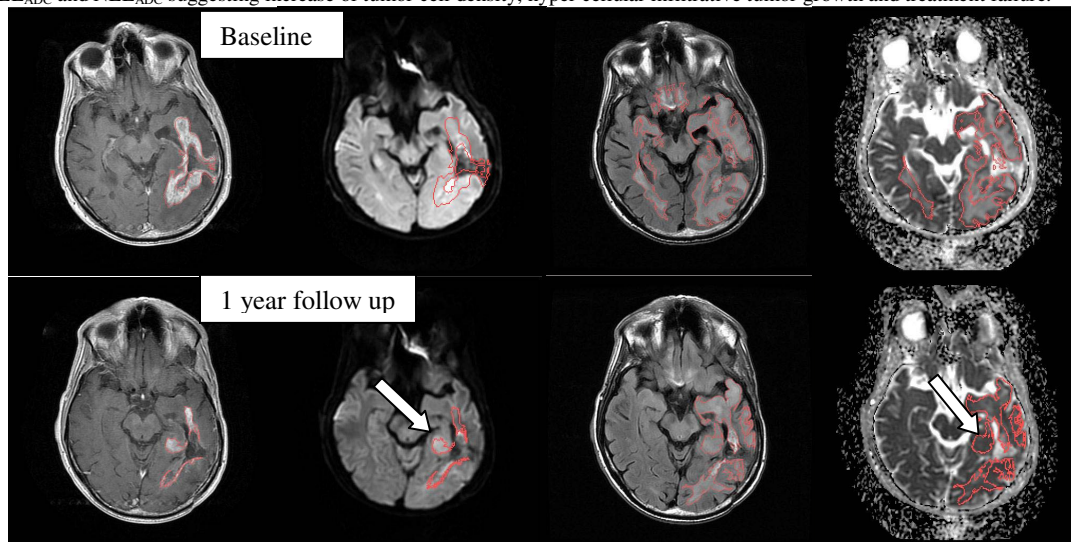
Baseline and 1 year follow up MRI in a non-responder with GBM showing interval decrease of CEL<sub>vol</sub> and NEL<sub>vol</sub>, however, there is infiltrative hypercellular lesion noted in the medial part of the temporal lobe (arrow) which shows reduced ADC values. CEL<sub>ADC</sub> and NEL<sub>ADC</sub> were both reduced at 1 year follow up as compared to baseline study.
